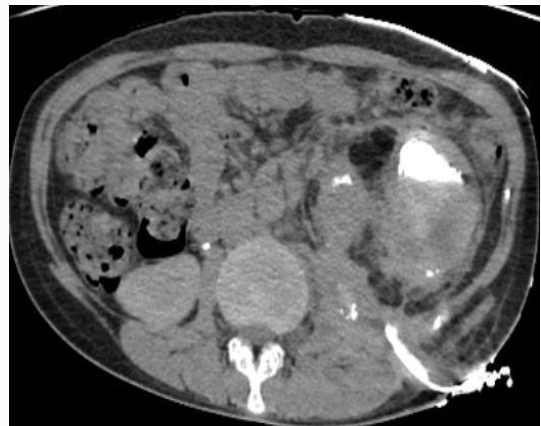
CT image depicting contrast flowing through the communication between skin, left kidney and left psoas muscle.
